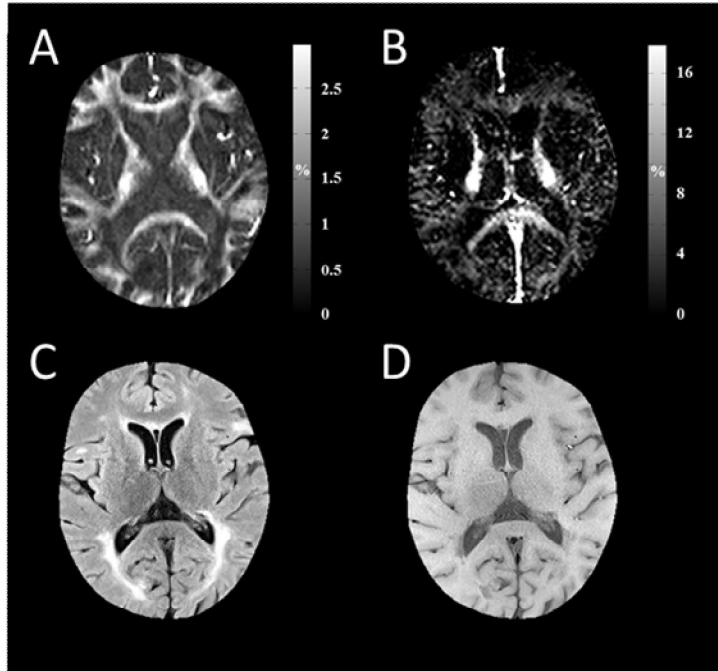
Representative images of ViSTa (A), GRASE (B), FLAIR (C), and T<sub>1</sub> weighted images (D) from a NMOSD patients.
